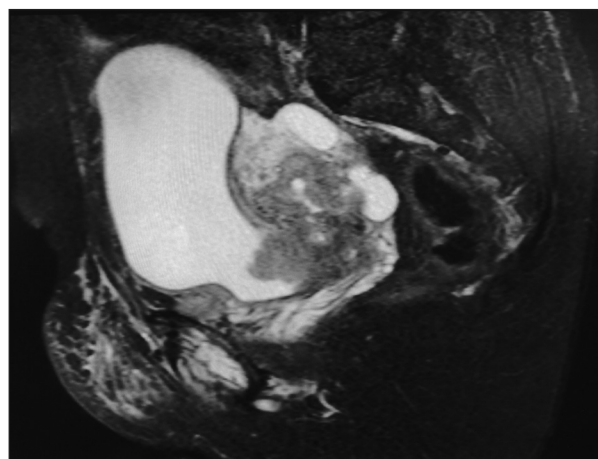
T1 Weighted magnetic resonance imaging showing invasion of the posterior wall of the bladder by the tumor growth
